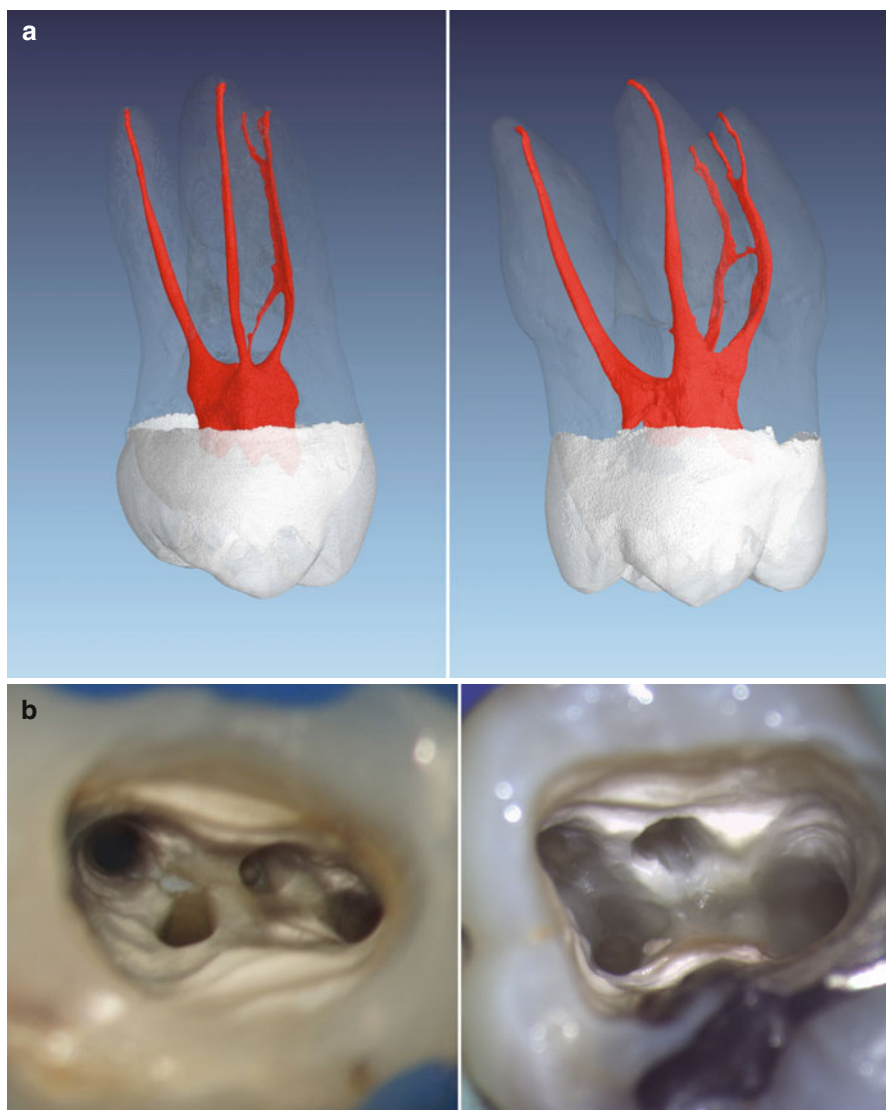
(a) Micro-computed tomography images of an extracted first (*right*) and second maxillary molar (*left*). Note the in general similar shape but the overall smaller volume of the second maxillary molar. Typically, the buccal roots of the second maxillary molar seem to be fused. (b) Clinical images of cases after preparation of all canals in a first (*right*) and second (*left*) maxillary molar with rotary instruments. The access cavities provide an overview of all four canal orifices. Note the ribbon-shaped pulpal floor in the second maxillary molar, the entrance of MB2 is located very close to the palatal orifice, a common finding in these kinds of teeth
